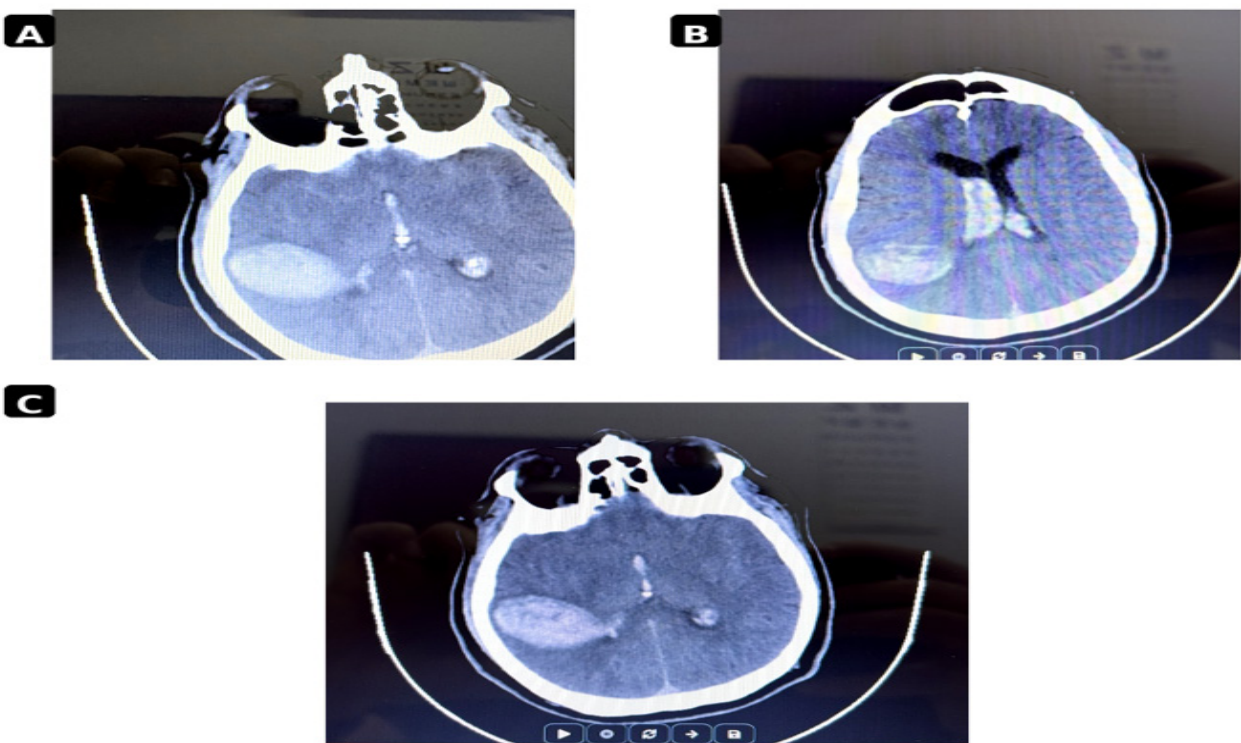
(A) Non-contrast axial brain CT demonstrating a large hyperdense intraparenchymal hematoma in the right temporoparietal region with surrounding edema and mass effect. (B) Axial CT image showing intraventricular extension of hemorrhage with hyperdense blood within the lateral ventricles. (C) Postoperative CT demonstrating residual hemorrhagic changes and ongoing ventricular system involvement.
